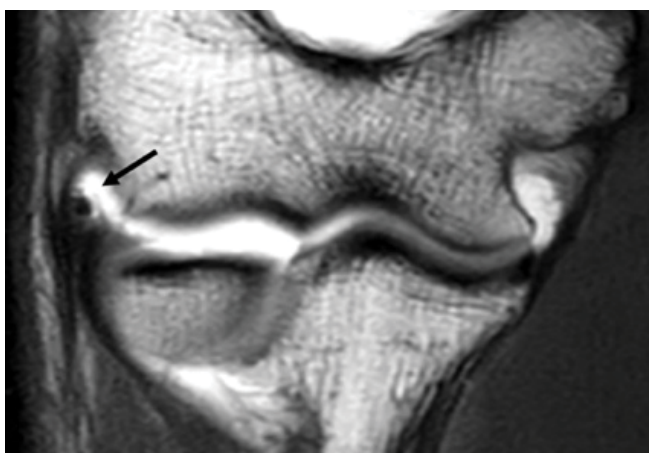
Coronal T1-weighted image: complete tear of the proper radial collateral ligament with intact common extensor tendon insertion.
